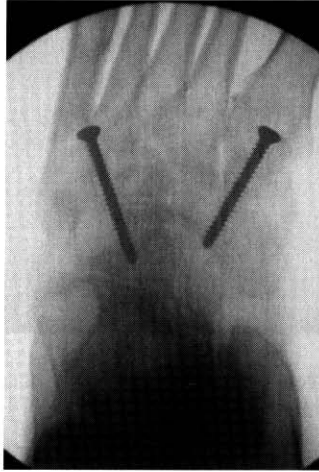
AP radiograph after reduction and fixation of midfoot osteotomy.
